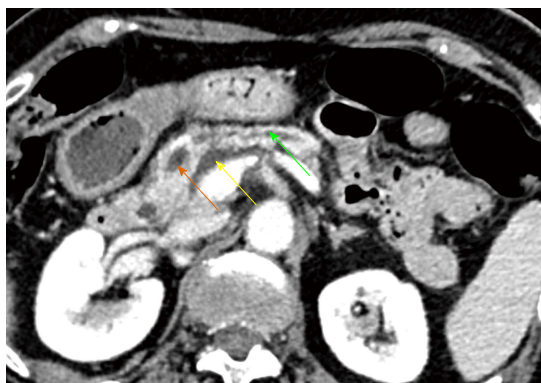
Patient suffered a mild acute pancreatitis 3 wk after radiofrequency ablation. CT revealed a peripancreatic fluid collection (yellow arrow) and tumour necrosis (orange arrow) with slight dilation of the upstream pancreatic duct (green arrow).
